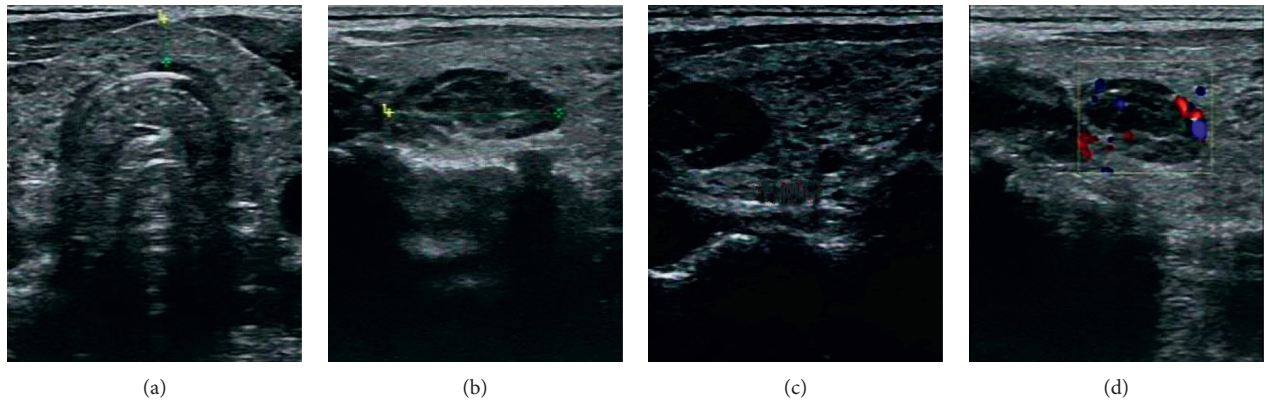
Conventional ultrasound and color Doppler ultrasound images of a 40-year-old female patient (ABC were conventional ultrasound images; C was a color Doppler image).
